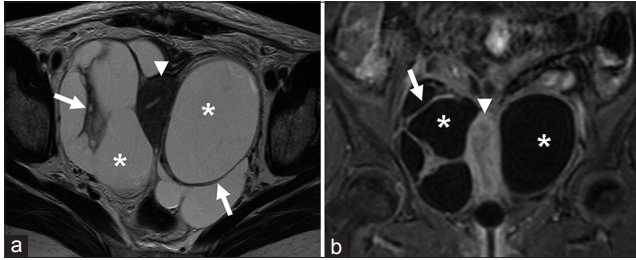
38-year-old woman with chronic tubercular hydrosalpinges. (a) Axial T2W MR image reveals bilateral (asterisk) multi-loculated high signal intensity (arrows) adnexal lesions with intercommunicating loculi owing to incomplete septae suggestive of hydrosalpinges. (b) Coronal T1W fat suppressed postgadolinium (arrows) MR image demonstrates heterogeneous enhancement of the septations with no nodules. Note the compressed uterus in the midline (arrowhead).
